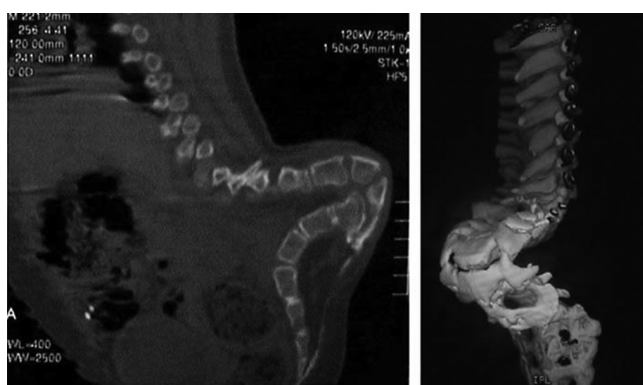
Sagittal views from pre-operative computerized tomographic (CT) scan and three-dimensional CT reconstruction (far right) of the thoracic and lumbar spine showing more anatomic detail than radiographs of the deformity, but insufficient detail to decide how many levels to remove and the precise fixation points for the instrumentation (patient B).
